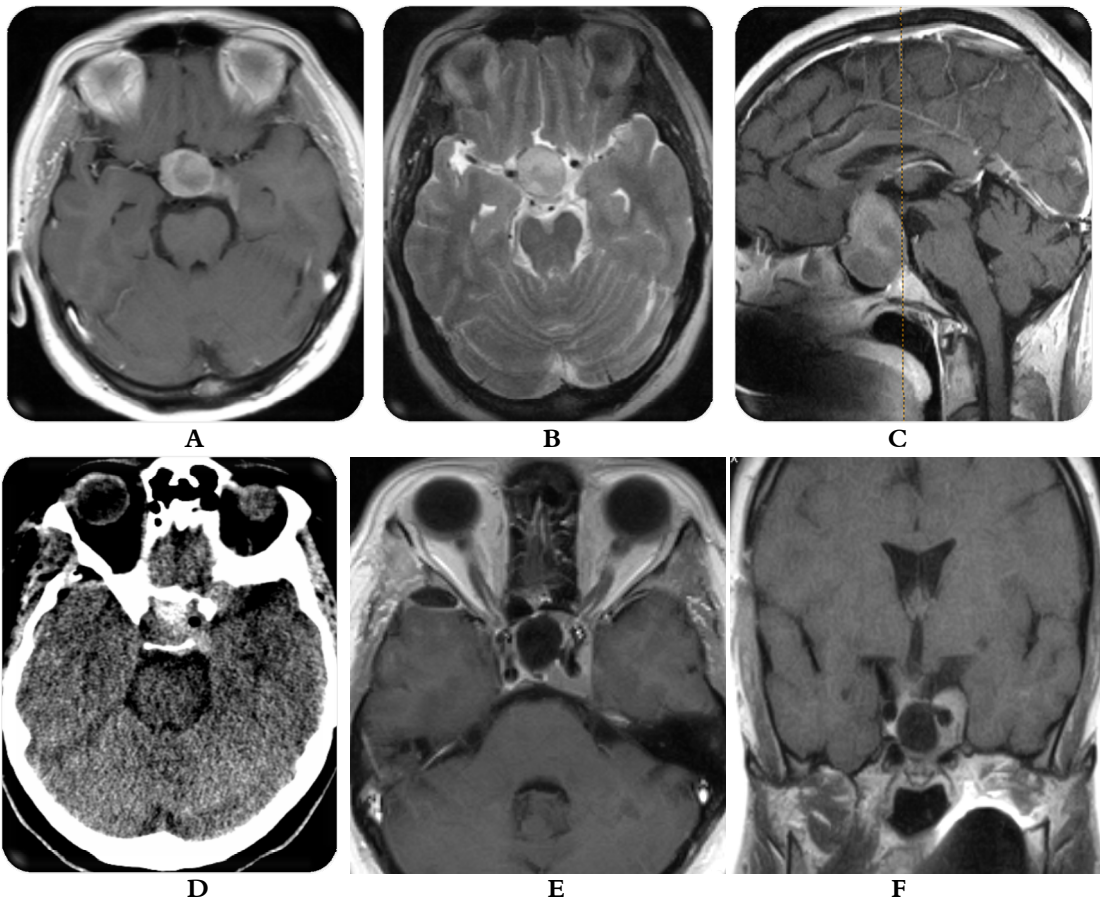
MRI examination T1 with contrast enhancement axial (A)/sagittal (C) and T2 axial showing a sellar and suprasellar mass hyperintense in T1 and axial T2 (B) with inhomogeneous contrast enhancement suggestive for pituitary apoplexy, (D) CT scan on 1st day postoperatively (transcranial) in the same 50y old F patient in treatment with Dostinex® for a known prolactinoma who presented with visual loss and impaired consciousness. (E) and (F) T1 contrast enhanced MRI at 3 months showing a residual tumor in the left cavernous sinus.
